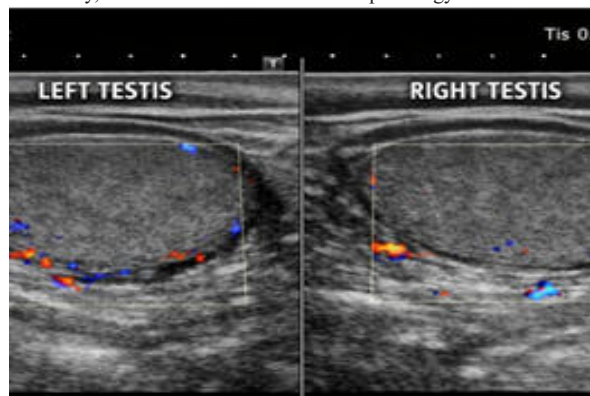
USG with colour doppler testes
